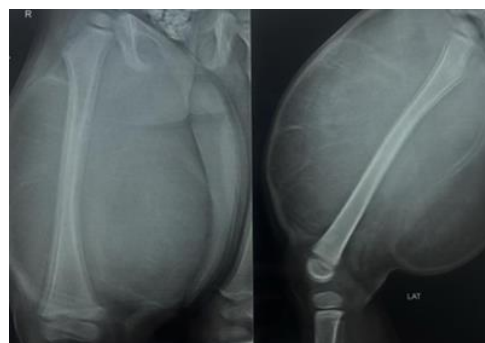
X-ray of the right thigh region shows a large mass; underlying bone is unaffected.
